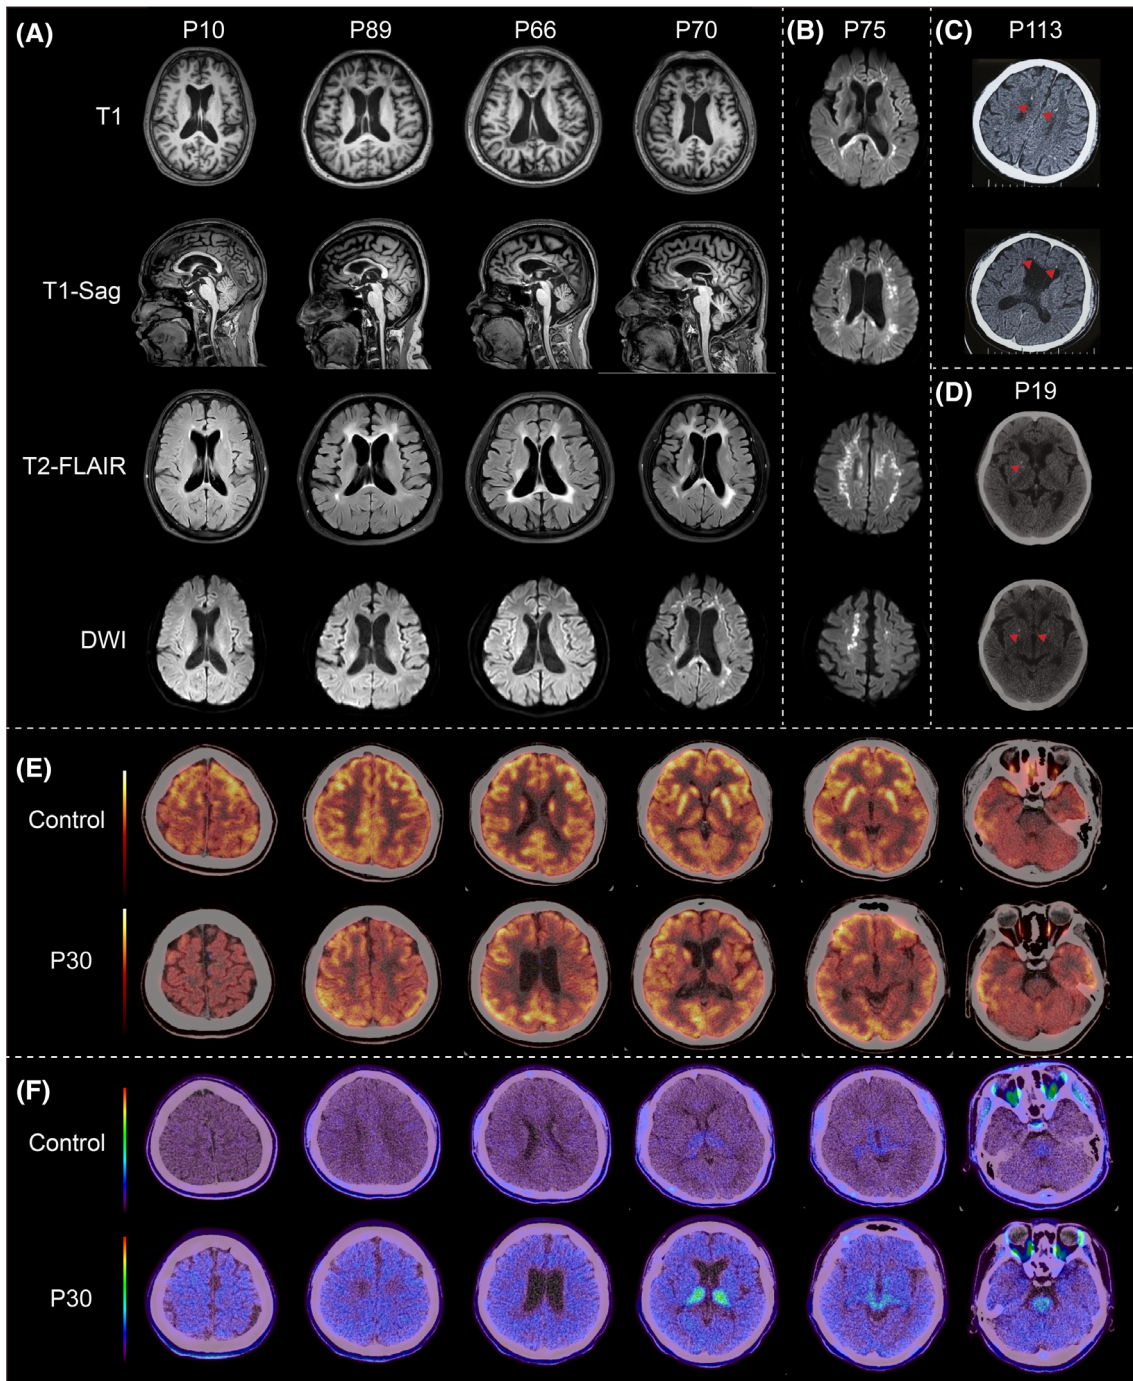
Radiological features of colony-stimulating factor 1 receptor-related disorder (CRD) patients in China. (A) MRI characteristics. P10 was featured with enlarged ventricles, but little white matter lesion. He is a 40-year-old man with an age of onset (AAO) of 39, carrying c.2381 T > C/p.I794T mutation and characterized with cognitive decline. P89 was featured with frontoparietal white matter lesions, with prominent cognitive decline but no influence in movement; she is a 51-year-old female woman, 2-year duration, carrying the c.2703_2706del/p.T902Sfs mutation. P66 was characterized with temporooccipital demyelination, consistent with prominent parkinsonism in clinical manifestations; she is a 50-year-old woman carrying c.2473G > C/p.E825Q mutation with an AAO of 48. P70 with diffuse leukoencephalopathy manifested with both dementia and movement disorders, is a 39-year-old man, and carries c.2680_2692del/p.895_897del with 2-year duration. (B) Extensive diffusion-weighted imaging (DWI) hyperintensities in white matter (P75). Male, 41 years old, carried c.2391 T > G/p.F797C mutation with prominent cognitive decline with an AAO of 40. (C) Punctuate calcification in white matters near the anterior horns of ventricles revealed by CT (triangles). Male (P113), 35 years old, with c.1939_1941del/p.V647del mutation. He started manifest with significant cognitive decline and parkinsonism at 35 and underwent MRI 9 months after onset. (D) Punctuate calcification in basal ganglia revealed by CT (triangles). Female (P19), 34 years old, carries c.2330G > A/p.R777Q mutation, mainly manifesting parkinsonism with an AAO of 33. (E) Diffuse hypometabolism in frontoparietal lobes revealed by [¹⁸F]FDG-PET/CT. (F) Extensive neuroinflammation in the thalamus and the midbrain revealed by [¹⁸F]DPA714-PET/CT. Images of (E) and (F) are all from a 39-year-old woman (P30) carrying the c.2567A > C/p.Y856S mutation with a duration of 2 years. The main clinical symptoms are bradykinesia and abnormal posture and balance. [Color figure can be viewed at wileyonlinelibrary.com]
